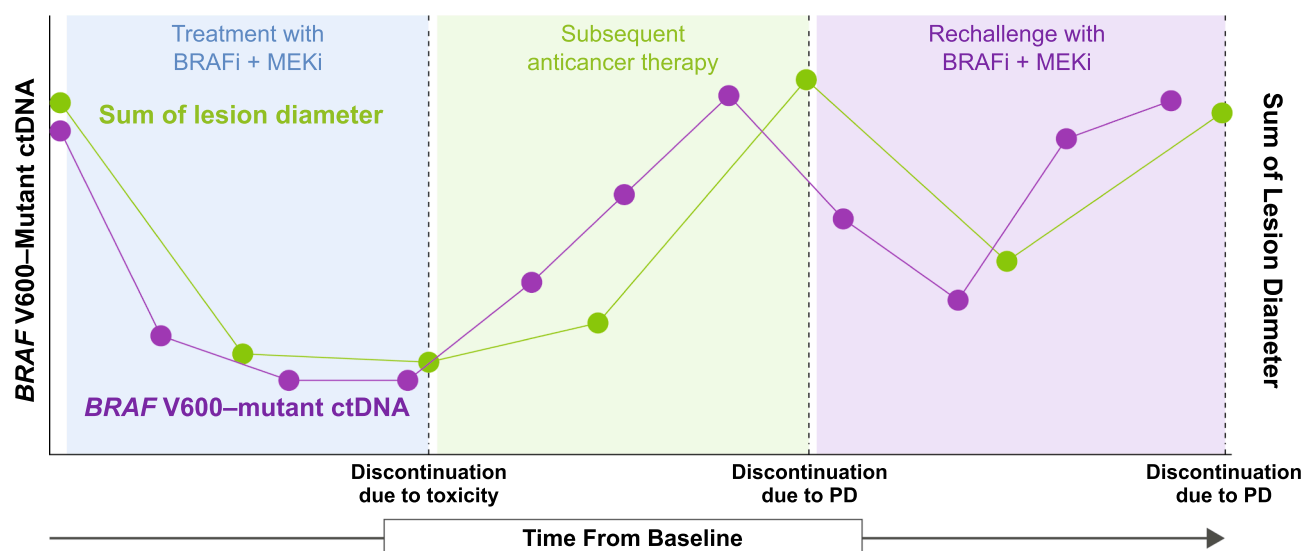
On-treatment monitoring of ctDNA: hypothetical patient journey. In this hypothetical patient case, a decline in ctDNA following initiation of BRAFi + MEKi treatment is observed prior to radiographic evidence of tumor reduction. Following discontinuation of targeted therapy due to toxicity and initiation of subsequent therapy, an increase in *BRAF*-mutant ctDNA is observed preceding radiographic evidence of progression. Following discontinuation due to progression, the patient receives rechallenge with BRAFi + MEKi therapy, which initially produces a response, initially observed as a reduction in ctDNA, followed by subsequent progression. BRAFi, BRAF inhibitor; ctDNA, circulating tumor DNA; MEKi, MEK inhibitor; PD, progressive disease.
